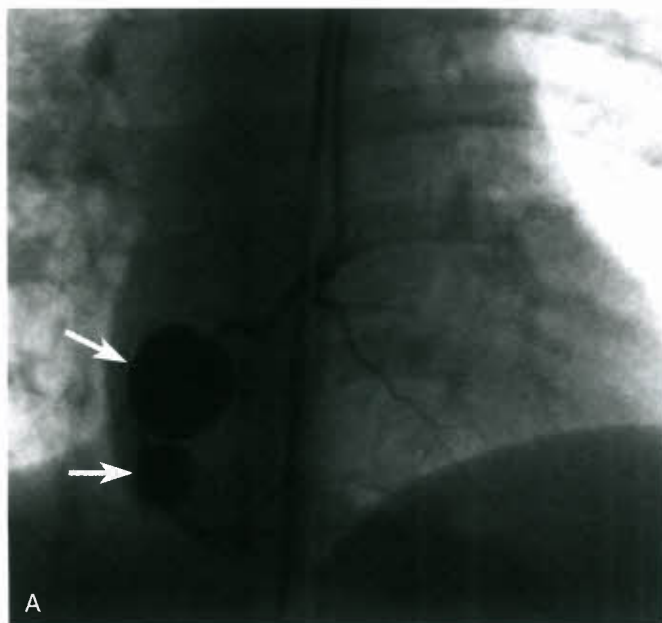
Selective coronary artery angiography in a patient with history of infantile Kawasaki disease and giant coronary aneurysms seen on echocardiography. A,B: Right coronary injection shows two large aneurysms (*arrow*).
